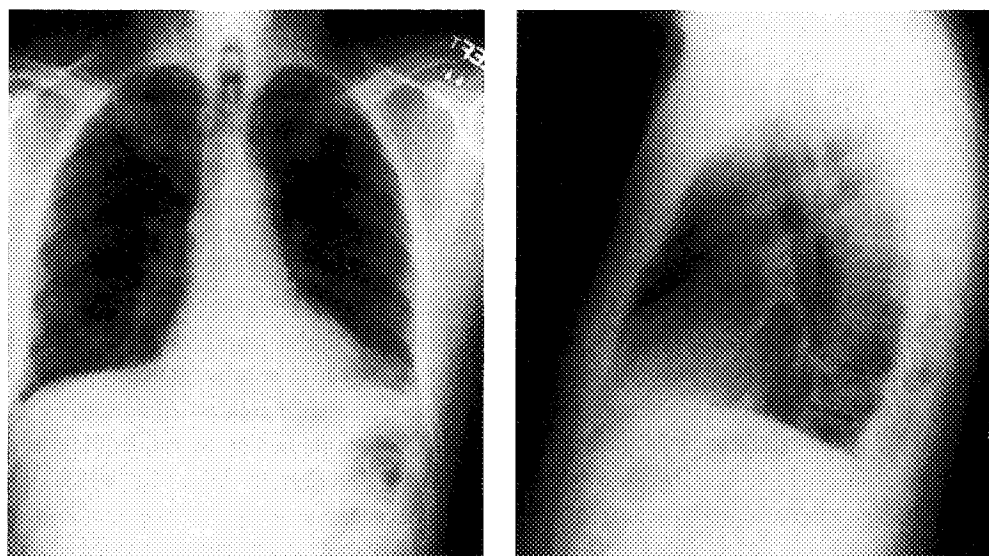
PA and lateral chest X-Ray, demonstrating bilateral small pleural effusions.
